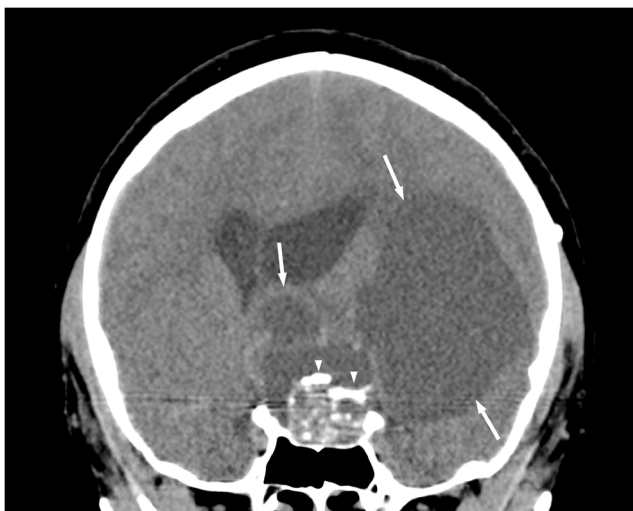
Suprasellar solid/predominantly cystic craniopharyngioma in a 12-year-old boy with headaches and blurred vision. Nonenhanced CT coronal image shows the large suprasellar lobulated hypoattenuating cystic component of the mass (*arrows*) extending superiorly, compressing the 3rd ventricle and causing hydrocephalus, and laterally to the left frontal and temporal regions with mass effect. Note the solid heterogeneous mass in the sellar/suprasellar region with coarse calcification (*arrowheads*)
